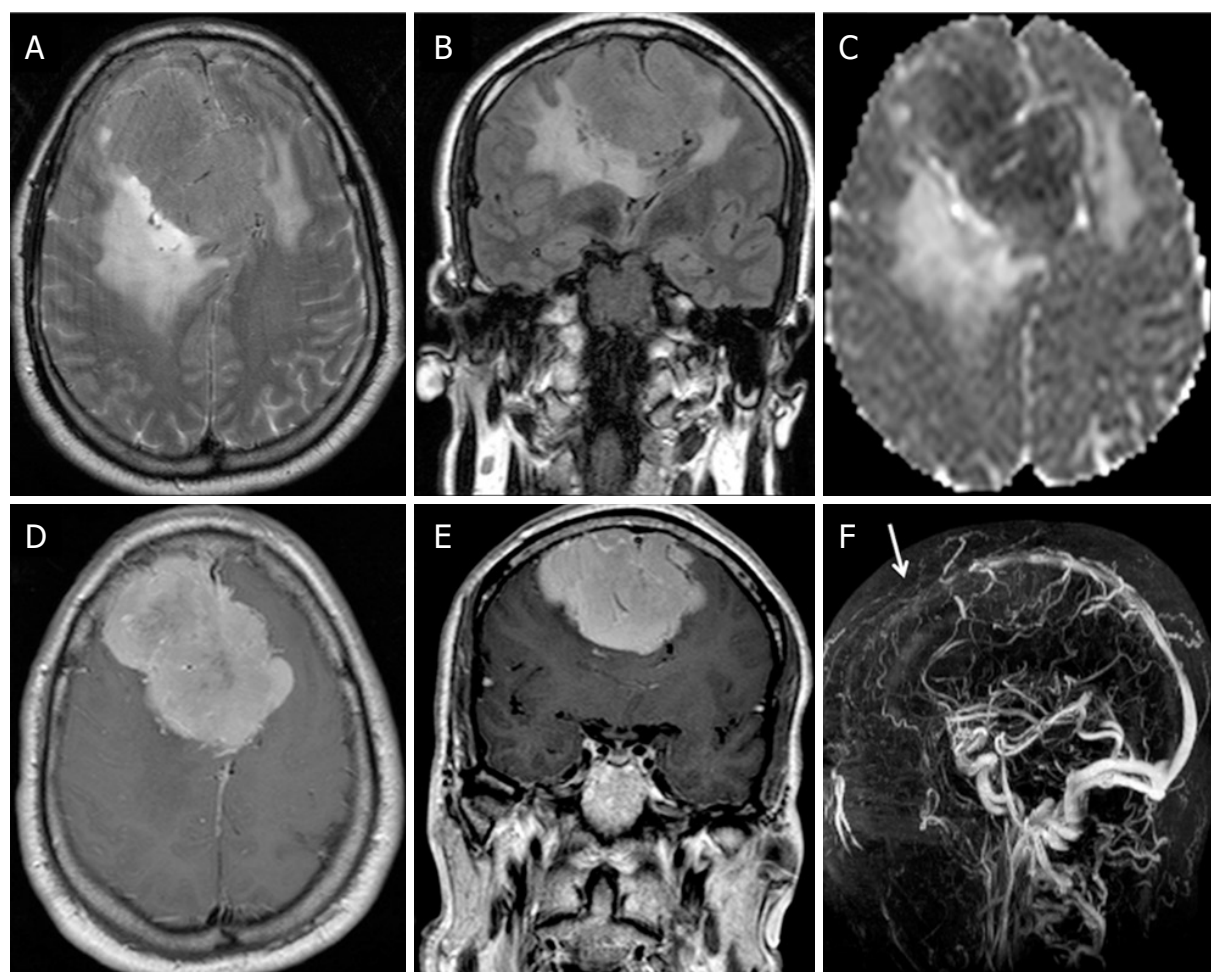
Falx cerebri high-grade meningioma on conventional MRI: inhomogeneous on T2w due to calcifications and necrosis (A), with large peripheral edema halo and no clear distinction from normal brain tissue on FLAIR (B); lower values compared to normal brain parenchyma on ADC maps (C); intense and inhomogeneous post-contrast enhancement after i.v. gadolinium administration (D, E); and invasion of the anterior segment of sagittal sinus on 3D PCA venogram (F). ADC: apparent diffusion coefficient
